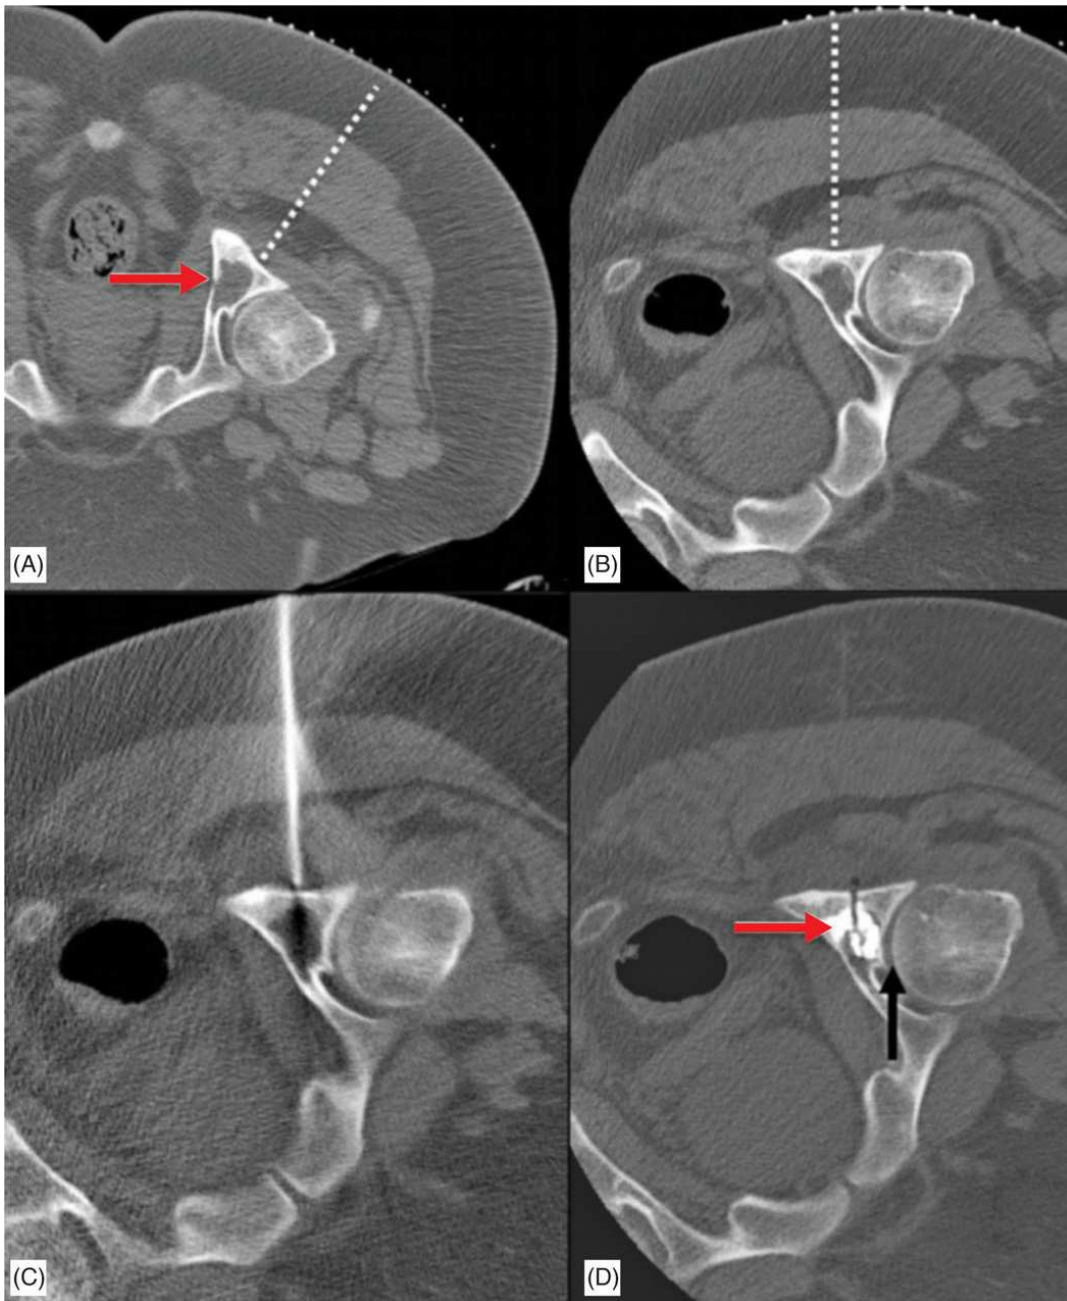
Oblique prone positioning to facilitate easier needle placement during acetabuloplasty. (A) Axial prone CT during planning reveals lucent mass in the posterior column of the acetabulum. With prone positioning, an oblique needle trajectory (dotted line) is required. (B) With oblique prone imaging a needle trajectory perpendicular to the floor (dotted line) is obtained, which is easier and less time consuming to achieve. (C) Imaging with 11-gauge needle in place, prior to cortical entry. (D) Postprocedure CT after PMMA injection (red arrow) and removal of needle, with no leakage into the hip joint (black arrow).
